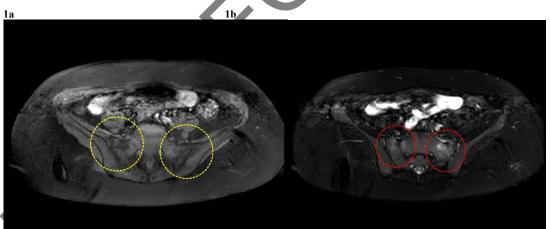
Axial plane sections of magnetic resonance imaging showing the bilateral sacroiliac joints. Sacral fractures are indicated by yellow and red dashed circles on both sides. T1-weighted (left) and T2-weighted (right) axial MRI images demonstrate hypointense signals (1a) and hyperintense signals (1b) localized to the bilateral sacral ala.
